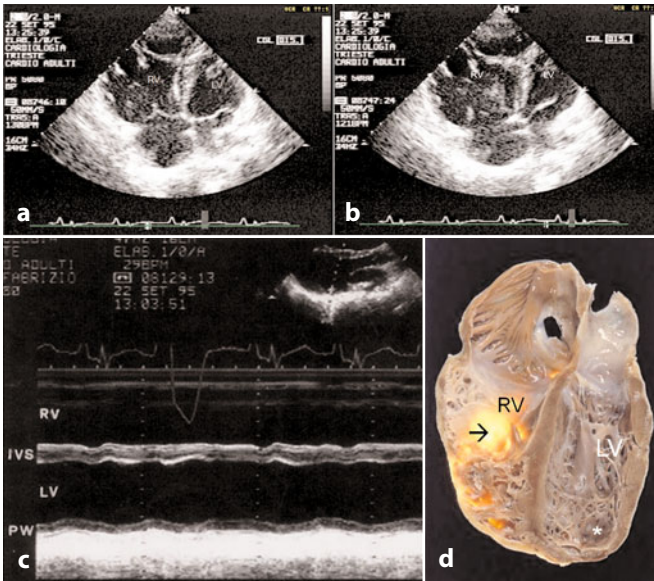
Arrhythmogenic right ventricular cardiomyopathy with left ventricular involvement. The patient died in refractory heart failure. End-systolic frame (a) and end-diastolic frame (b) of two-dimensional echocardiography, apical four-chamber view oriented to the right ventricle (RV). The RV is severely dilated and diffusely hypokinetic with multiple akinesic bulges of the free wall; systolic function was severely depressed. The left ventricle (LV) is not enlarged, but diffusely hypokinetic. c M-mode echocardiogram (parasternal approach) at the level of the ventricles. The RV is enlarged (end-diastolic diameter 45 mm). The LV is not enlarged (end-diastolic diameter 55 mm), but severely hypokinetic (fractional shortening 18%). d Severe RV dilatation with fatty infiltration shown by transillumination (arrow). In the LV, there is a small apical aneurysm (asterisk). IVS, interventricular septum, PW, posterior wall
